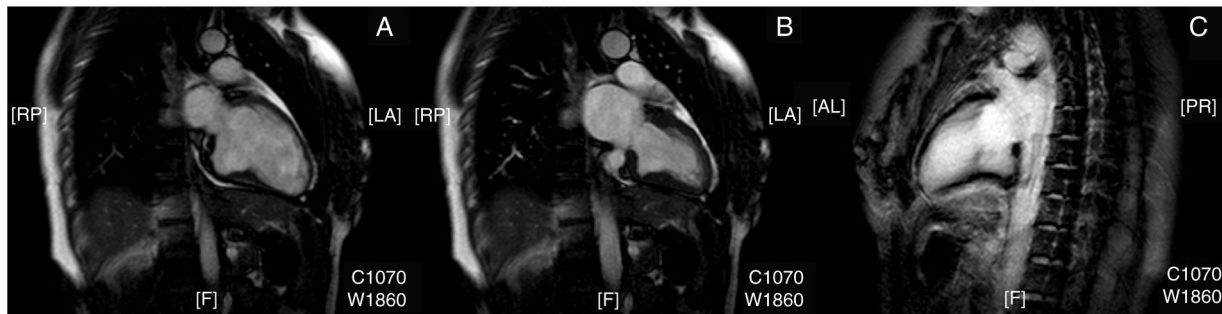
Magnetic resonance imaging study. Two-chamber end-diastolic (A) and end-systolic (B) views showing the normal contractility of the anomaly. (C) Absence of late gadolinium contrast uptake.
